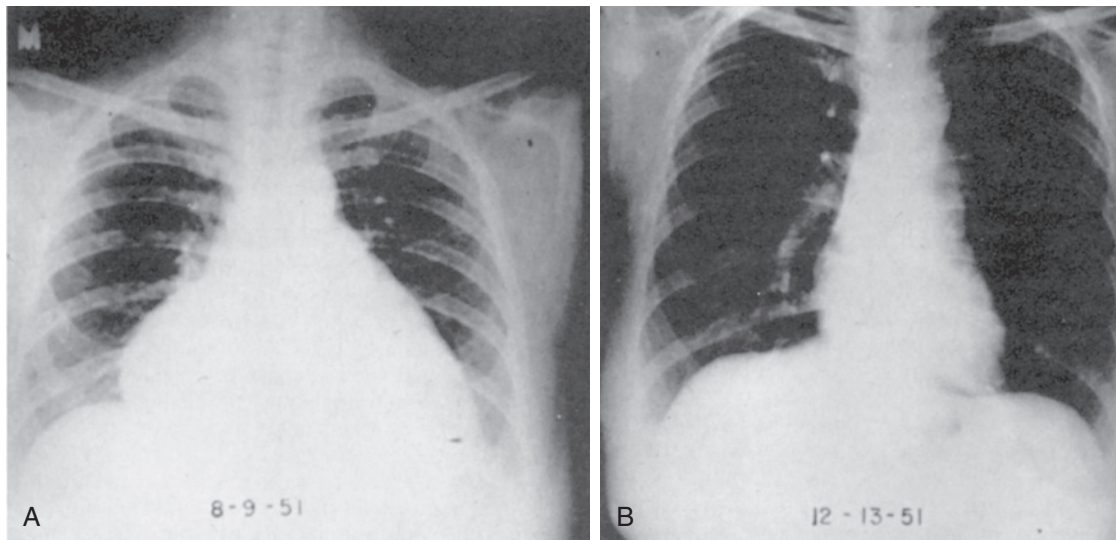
A, Radiograph showing enlargement of the heart in a patient with heart failure caused by myxedema. B, After treatment with thyroid hormone, the radiograph shows a return to normal heart size. (From Melmed S, et al: *Williams textbook of endocrinology*, ed 12, Philadelphia, 2011, Saunders.)
